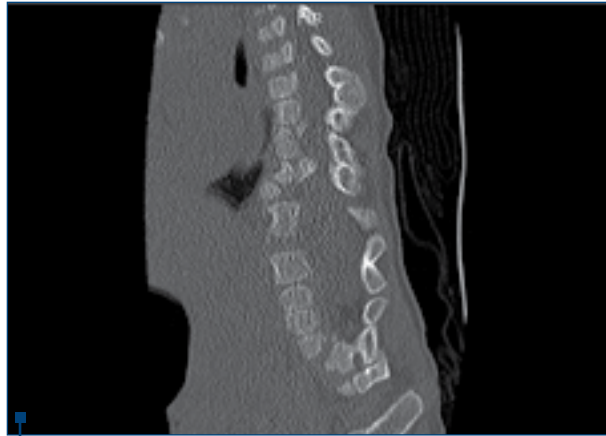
Postnatal CT scan (at 13 months) - severe disorder of the vertebrae
